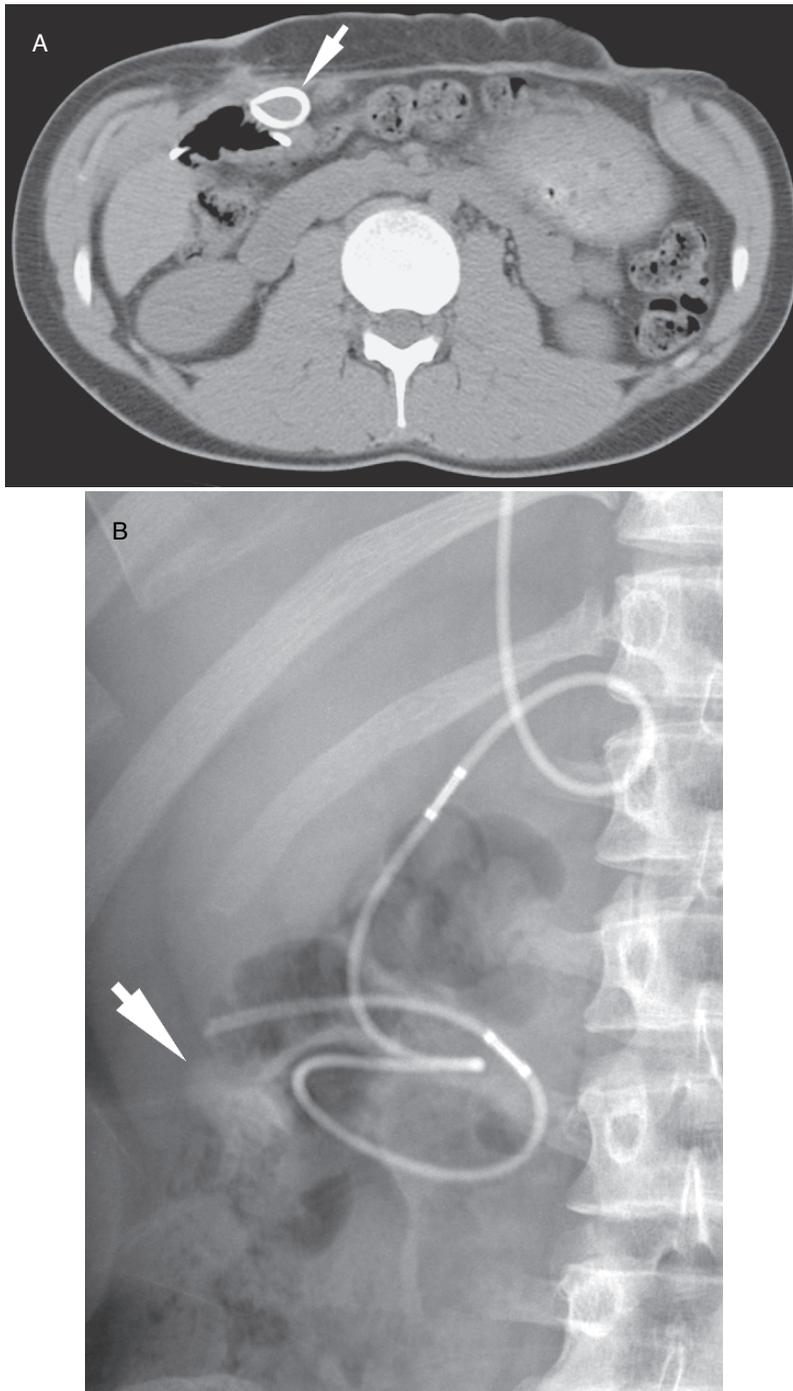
Bowel perforation. (A) CT scan shows the VPS (arrow) inseparable from the small bowel with minimal surrounding inflammation. (B) Shunt contrast study shows contrast passing from the shunt into the bowel (arrow) confirming bowel perforation.
